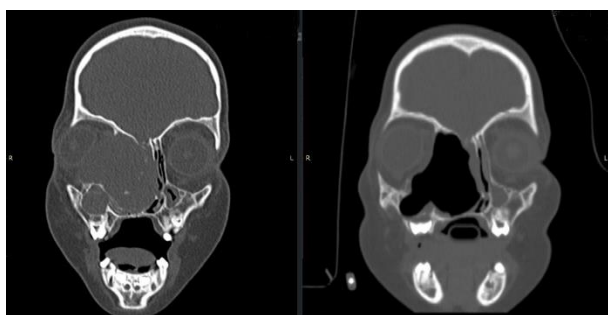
Comparative coronar CT preoperative (left) and postoperative (right)
